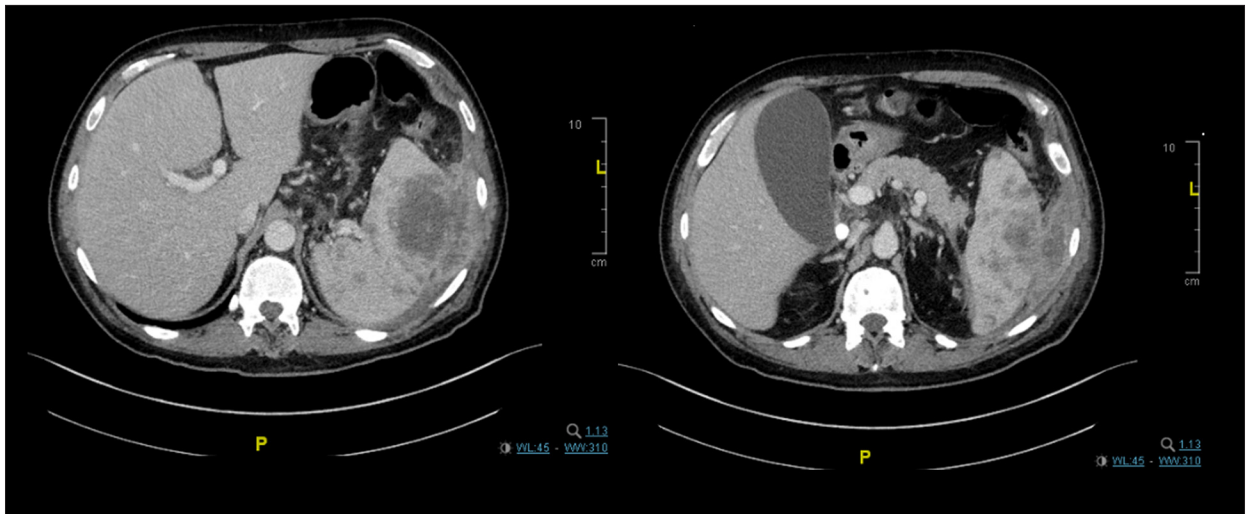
Accidental spleen nodules. Axial contrast-enhanced abdomen computed tomography scan (2 sections) showing gallbladder hydrops and splenomegaly (spleen bipolar diameter: 14 cm) with parenchymal alterations characterized by several abscess-like splenic hypodense nodules. Presence of peri-splenic fluid collection.
